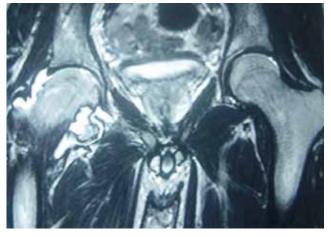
T_2 -weighted coronal magnetic resonance imaging of pelvis. Note edematous prominent lesion at inferior border of head-neck junction.
